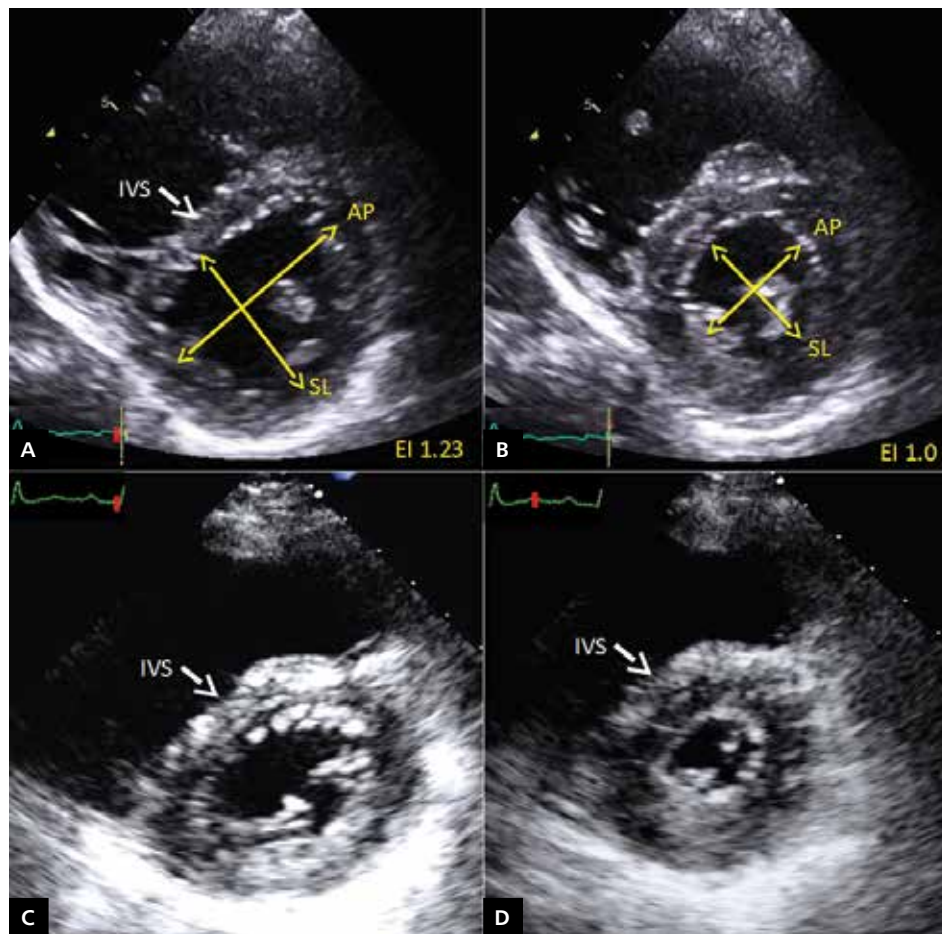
Assessment of the right ventricular (RV) shape and interventricular septum (IVS) motion in parasternal short-axis view at the level of papillary muscles. Stop-frame two-dimensional echocardiography images from a patient with an isolated RV volume overload due to severe tricuspid regurgitation (A, B) and from a patient with pressure overload due to primary pulmonary hypertension (C, D). In patients with RV volume overload the leftward septal shift and flattening are observed during diastole with left ventricle (LV) taking the shape of the letter 'D' (A), whereas a circular profile of LV cavity is maintained during systole (B). In patients with RV pressure overload the septal flattening and deformation of the LV are maintained also during systole (C, D). Eccentricity index allows the quantitation of the LV shape changes by dividing LV antero-posterior diameter (AP) by septo-lateral diameter (SL), during both systole and diastole. An eccentricity index (EI) value greater than one at end diastole is a strong indicator of RV volume overload (A). At end systole or during the whole cardiac cycle it suggests the RV pressure overload
